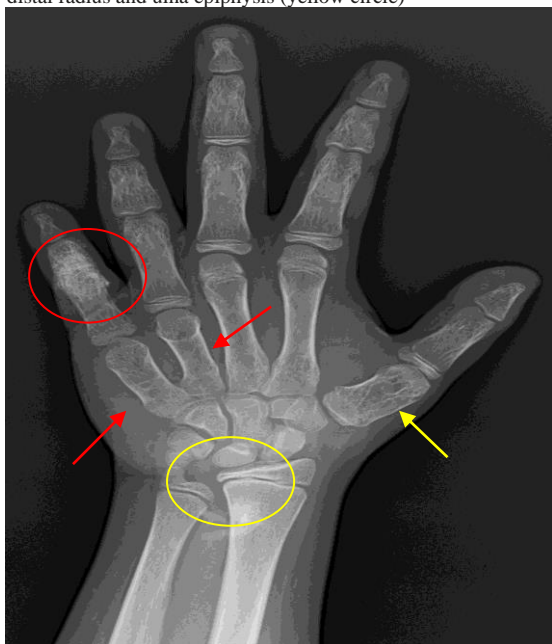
Left hand and wrist x-ray of first sister
